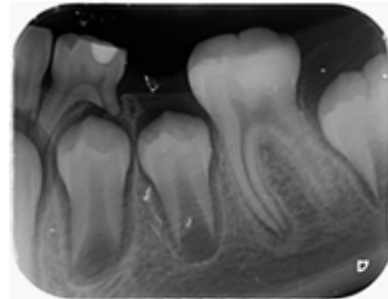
Initial periapical radiograph of tooth 3.6.
